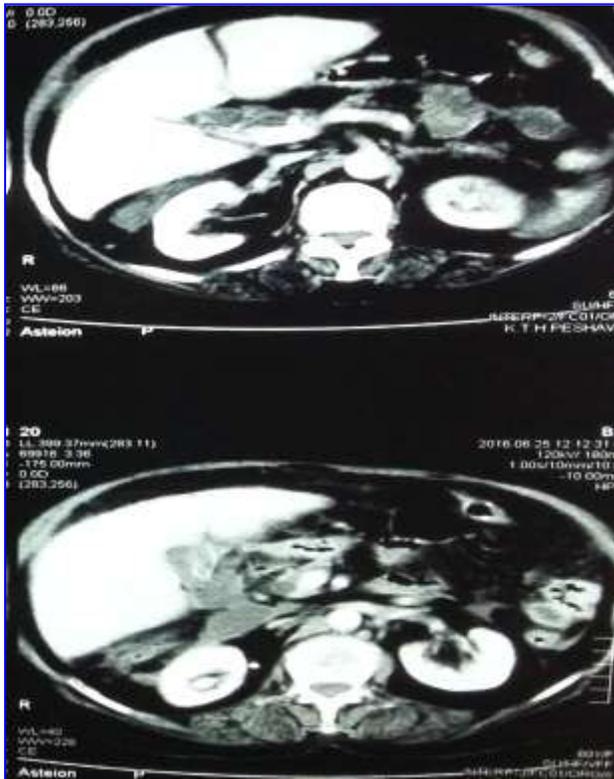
Abdominal CT scan showing pneumobilia and fistulous communication between gallbladder and duodenum
